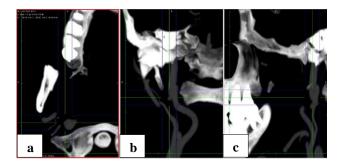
Brain angiography CT scan (a) the episode of admission using axial, (b) coronal, and (c) sagital view showed extracranial right internal carotid artery dissection with dissecting aneurysm.
